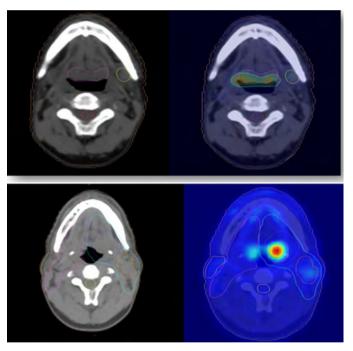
Delineated Volume in Planning CT vs. PET/CT.
